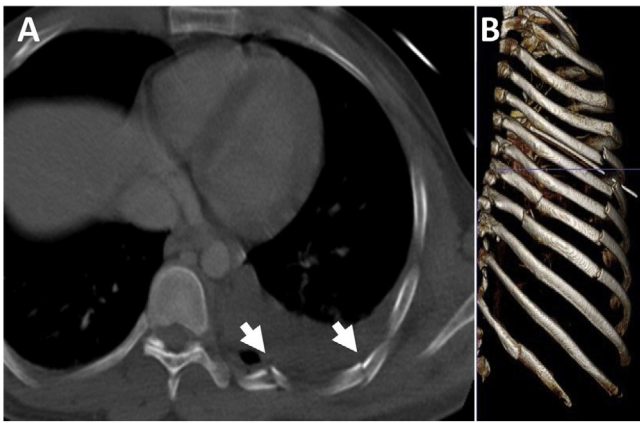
50-year-old male involved in a motorcycle accident, with flail chest. Axial chest CT image (bone window) (A) and 3D reconstruction (B) show two fractures in more than three contiguous ribs (arrows). Flail chest is a marker of severity and may be associated with paradoxical breathing.
